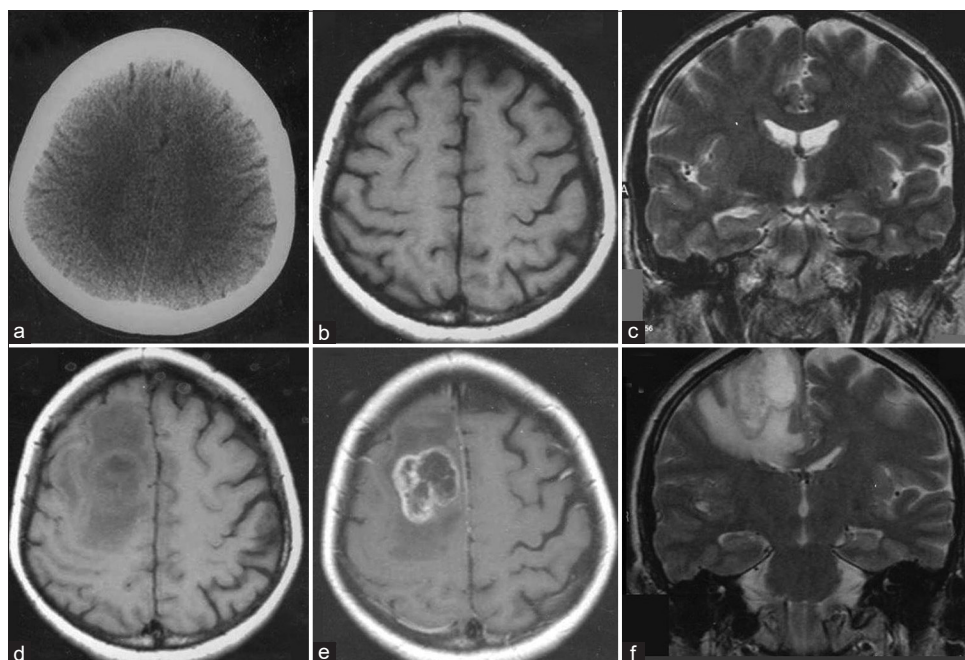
Case 1. Initial noncontrast axial computed tomography (a) and T1-weighted (b), and coronal T2-weighted magnetic resonance imaging (c) with no abnormality. Noncontrast T1-weighted magnetic resonance imaging demonstrated a mass lesion in the right frontal lobe (d), with heterogeneous contrast enhancement and necrosis on postcontrast axial T1-weighted magnetic resonance imaging (e) and hyperintense areas with strong edema on coronal T2-weighted magnetic resonance imaging (f) 4 months later
